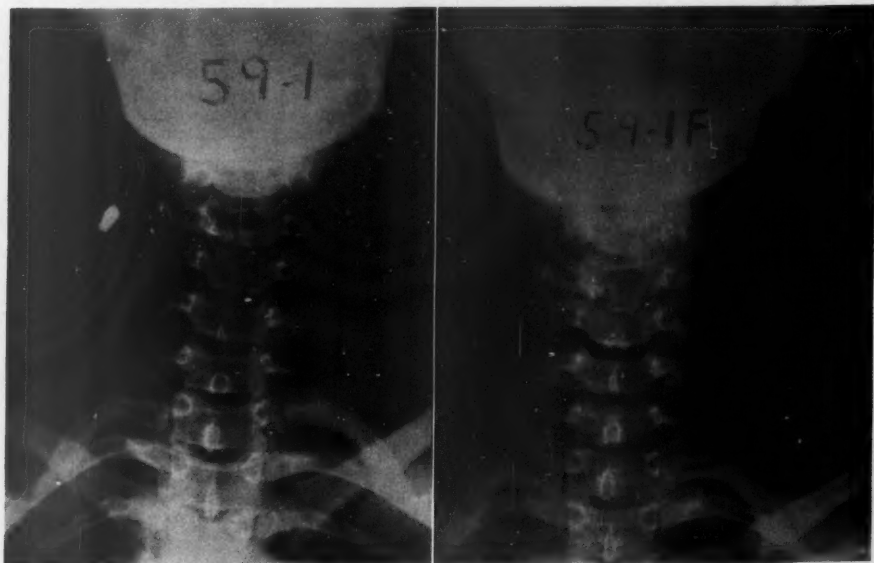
Case 4.* A 15-year-old white girl with bullet wound to C-4 resulting in Brown-Sequard syndrome plus left upper monoplegia and left lower monoparesis. Note that the left facet joint of C-4 has been shattered by missile after its course completely through the body of C-4. Lumbar puncture was normal. Posterior decompression was not done. The x-ray on the *right* was made postoperatively.
